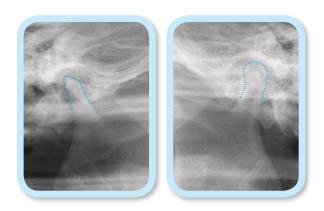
Post-treatment TMJ transcranial radiographs show that the condylar heads returned to symmetrical kinematics. There is no compression on the right side.
